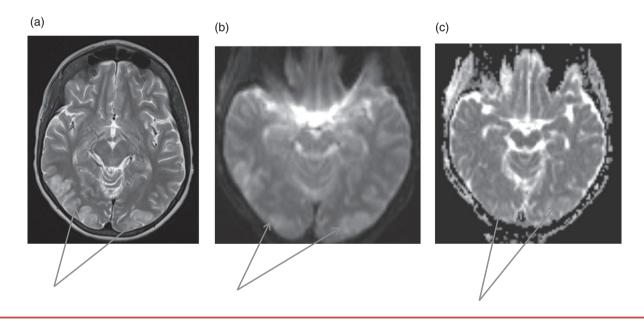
Stroke mimic/posterior reversible leucoencephalopathy syndrome. Fifteen-year-old male with sickle-cell disease and nephrotic syndrome on prednisolone and cyclosporine A presented acutely with left-sided eye deviation, left focal seizures, and left-sided weakness. His blood pressure was 180/110 and magnetic resonance imaging showed increased T2 signal bilaterally affecting parietal and occipital lobes asymmetrically. There was no evidence of restricted diffusion on diffusion-weighted imaging (b) and apparent diffusion coefficient maps (c). He made a full recovery. The imaging characteristics were critical for establishing the right diagnosis.
